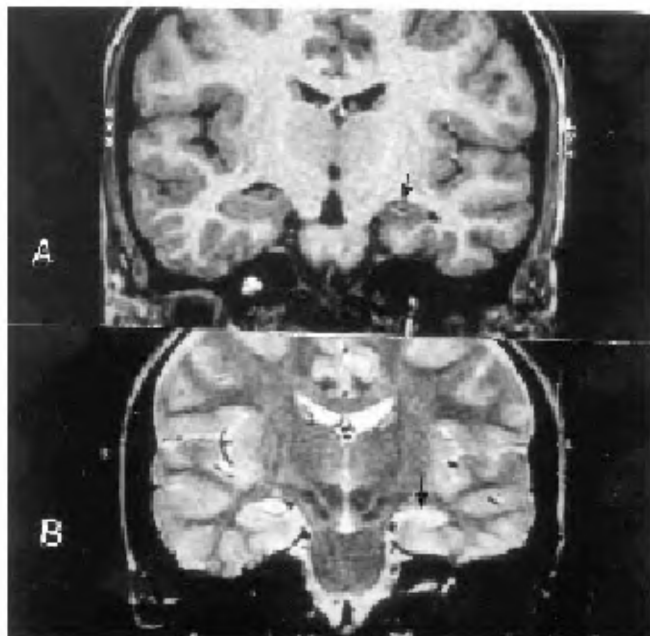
MRI in a patient with left hippocampal atrophy and sclerosis (pathologically confirmed after anterior temporal lobectomy and amygdalohippocampectomy) shows (arrows): (A) small hippocampus in T_1 -weighted sequence, and (B) increased signal in T_2 -weighted sequence.
